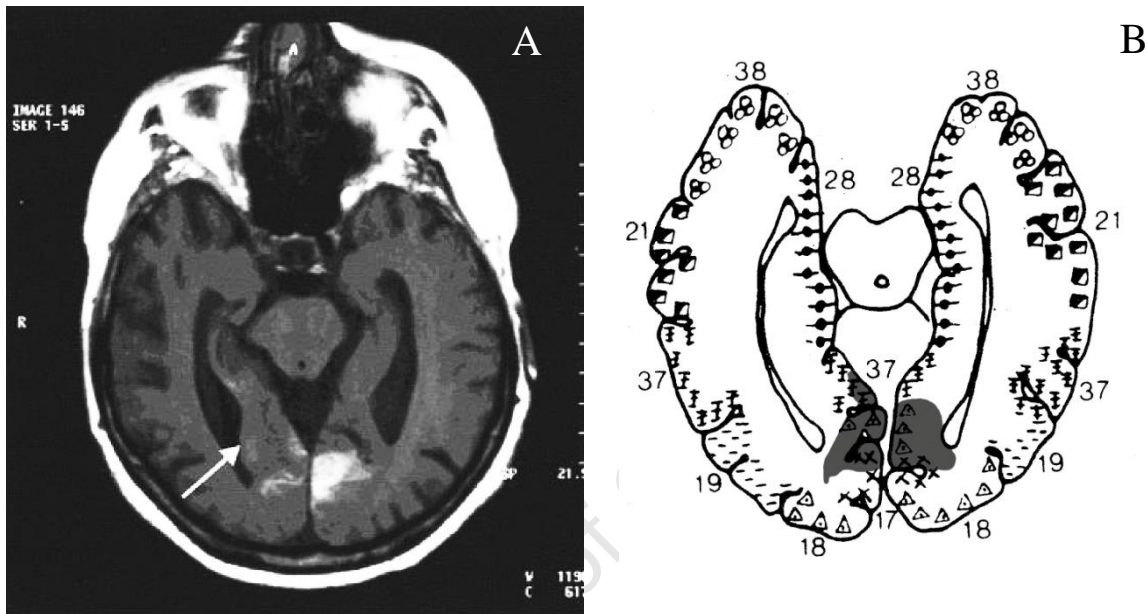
A) Original MRI-brain of Bischof and Bassetti's (2004) case. B) Brodmann's template showing lesion site in A.
